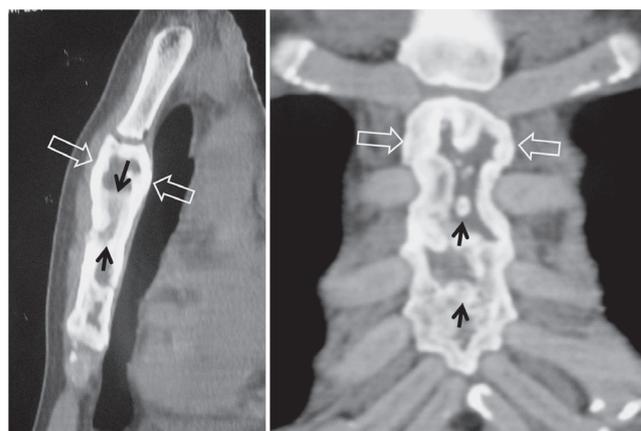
A 23-year-old male patient with primary non-Hodgkin lymphoma of the sternum. Sagittal (left) and oblique coronal (right) CT reconstructions showing bone expansion (open white arrows), cortical thickening and sclerosis in the bone marrow (black arrows).
